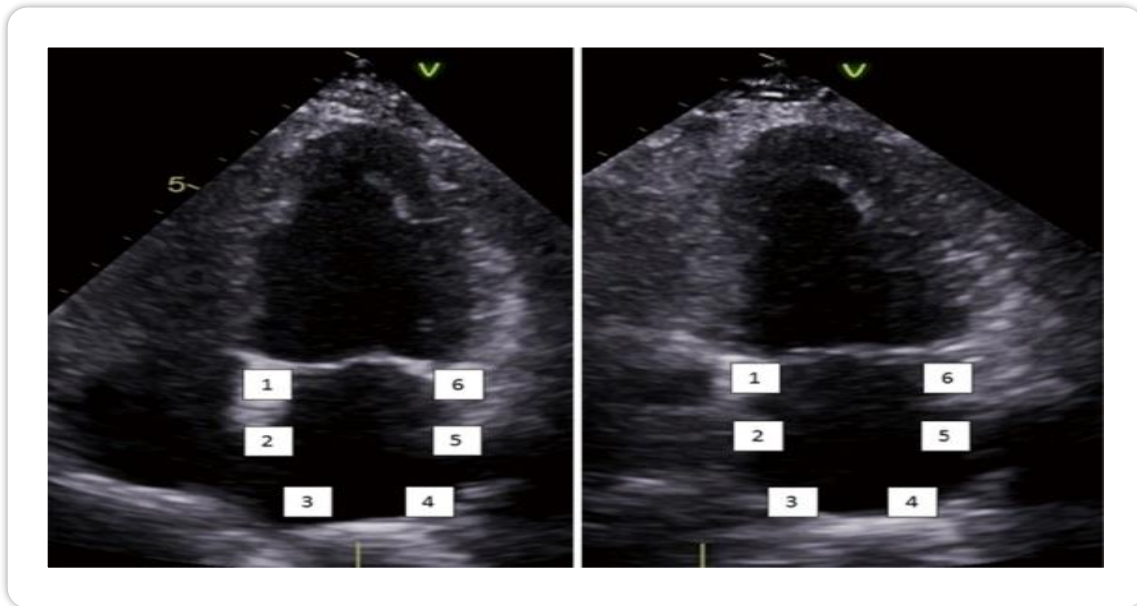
Apical four and two chambers [22].
